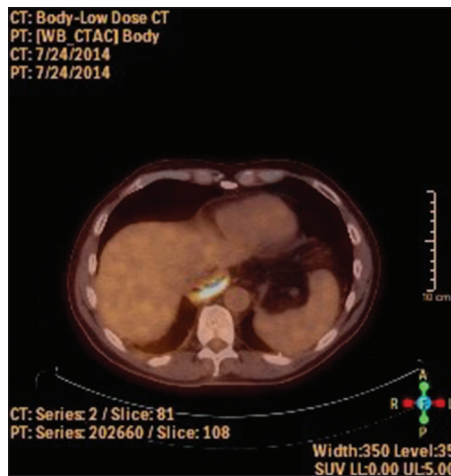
Computed tomography-positron emission tomography image showing linear hypermetabolic activity along the posterior margin of the distal pull through
